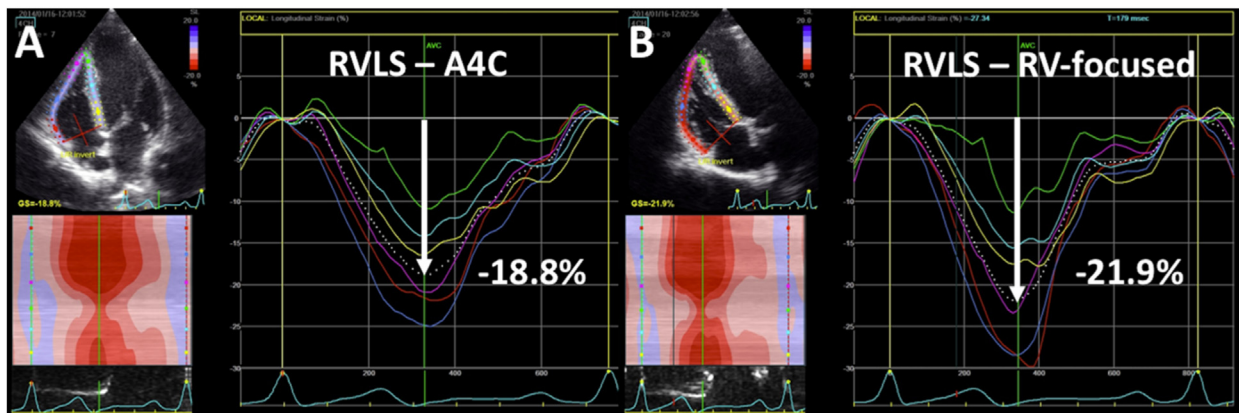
Demonstration of different RV strain value acquisition from variations of RV transthoracic windows. Obtaining RV strain measures from the apical RV-focused view is more accurate. Here is an example of incrementally higher RV GLS obtained from an apical RV-focused view compared with an apical four-chamber (A4C) view.
